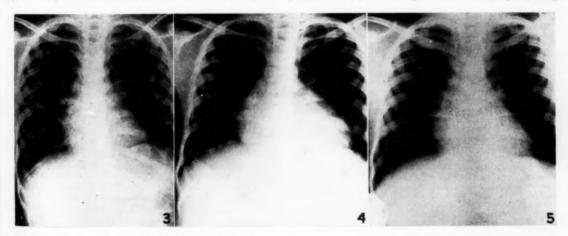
X-ray of chest showing heart size on admission.
